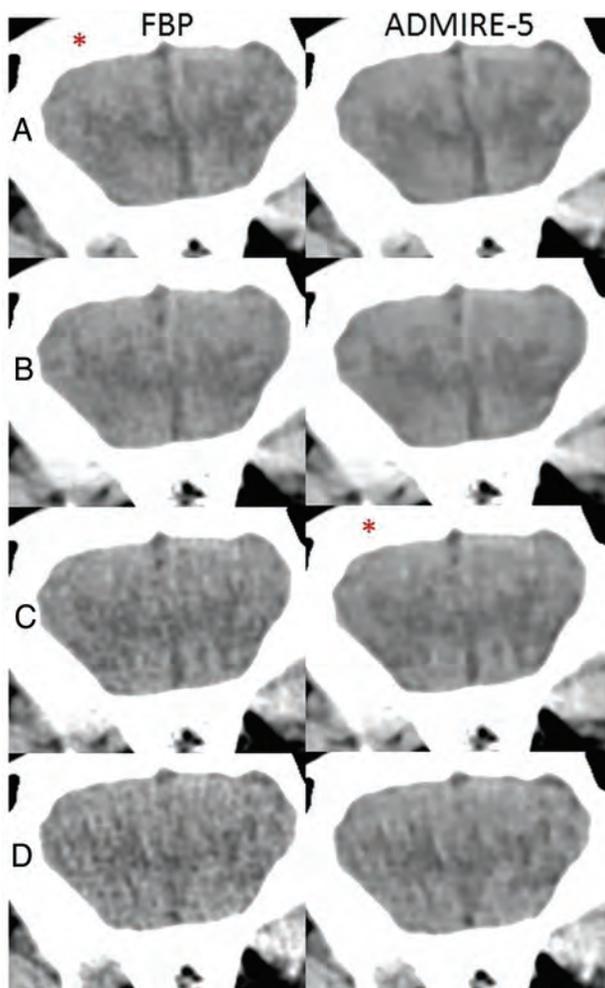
Sample coronal head CT images comparing FBP (left column) and ADMIRE-5 (right column) at the reference dose (A), 8% dose reduction (B), 58% dose reduction (C), and 75% dose reduction (D). Gray-white detectability and image texture were subjectively scored as equivalent between the reference dose with FBP (left, A) and a 58% dose reduction with ADMIRE-5 (right, C) as marked with an asterisk.
